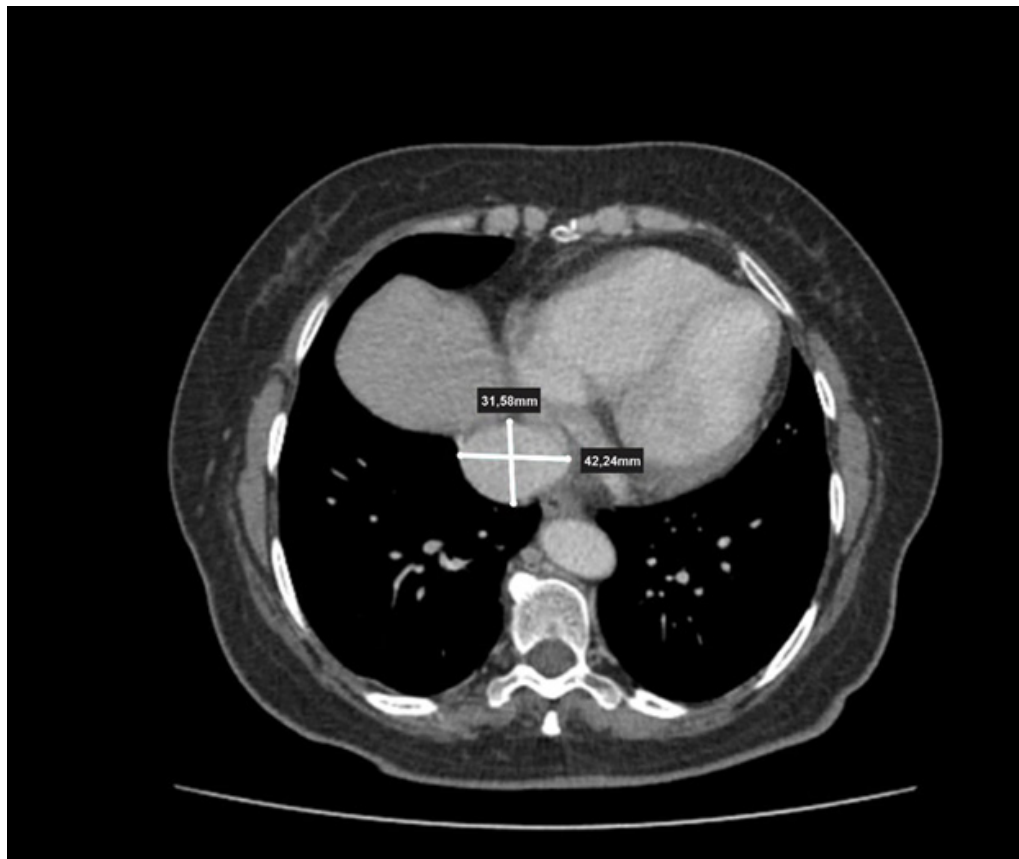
Chest computed tomography with IV contrast administration, axial section, showing an inferior vena cava aneurysm measuring 42.24 mm in the largest diameter and 31.58 mm in the smallest diameter (white lines).
